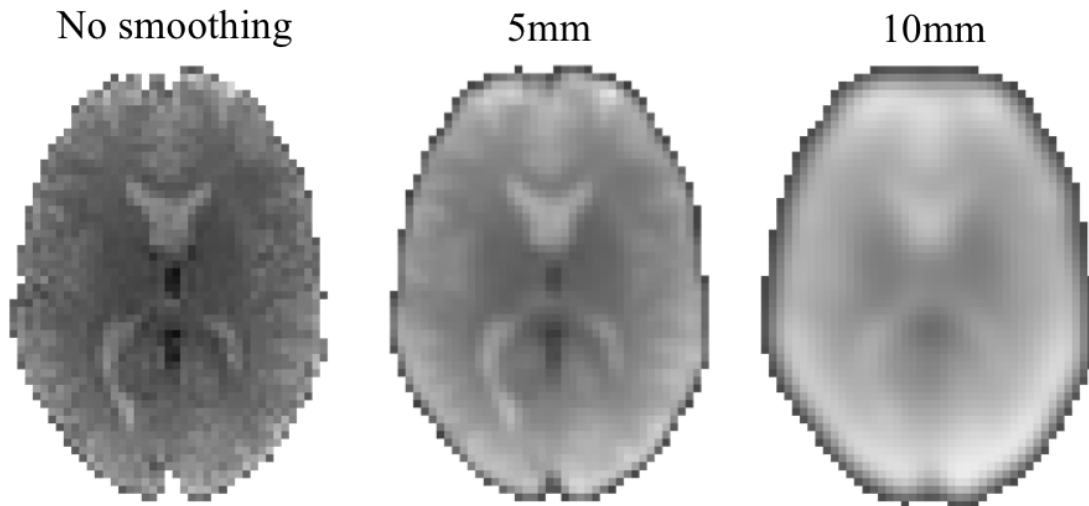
Spatial filtering. Spatial filtering enables an image to be smoothed to increase SNR, however it has the effect of blurring the image, as can be seen in this figure demonstrating the appearance of the same functional MRI image with no smoothing, smoothing with a 5mm and with a 10mm full width half maximum Gaussian kernel.
